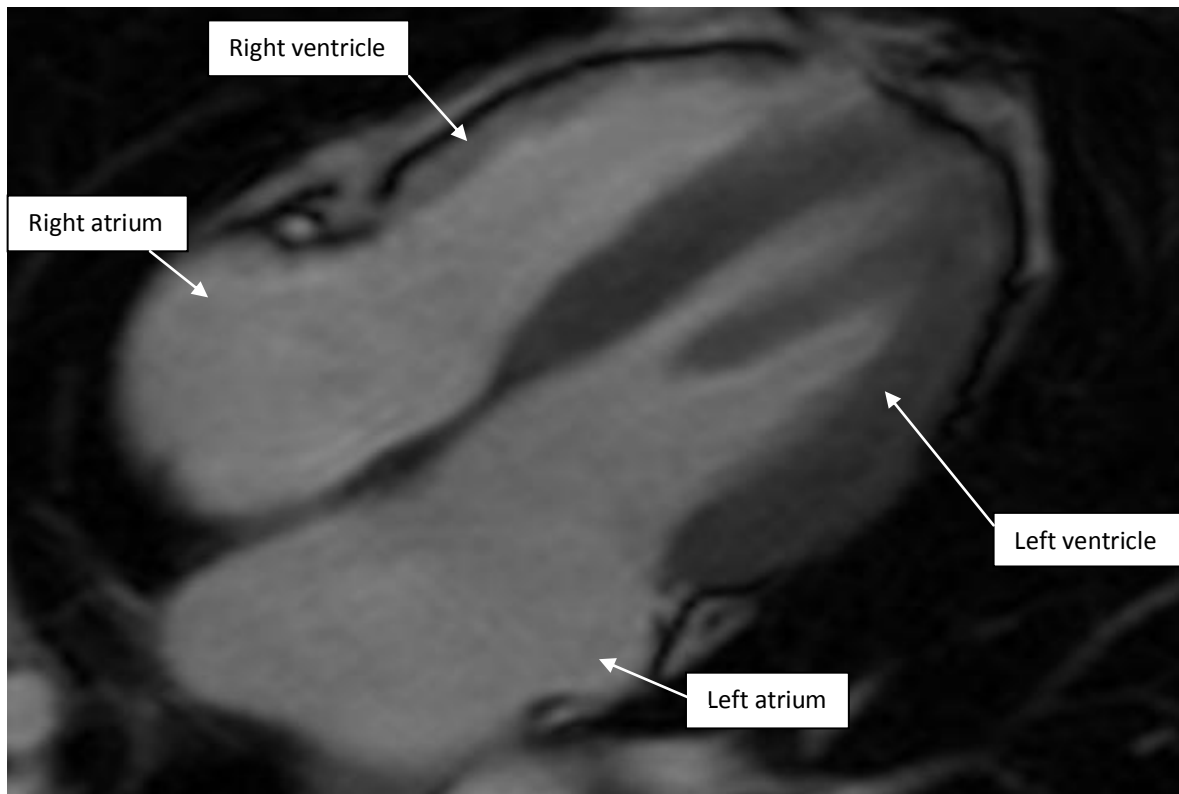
MRI CINE four chamber (horizontal long axis) view at systole
